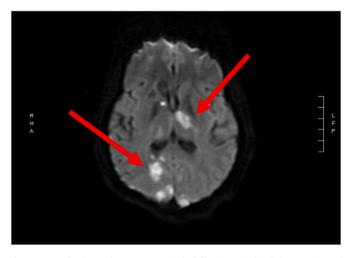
MRI brain with contrast, axial diffusion weighted image showed extensive acute infarctions in the right and left occipital lobes and basal ganglia, and a subacute caudate lesion.
